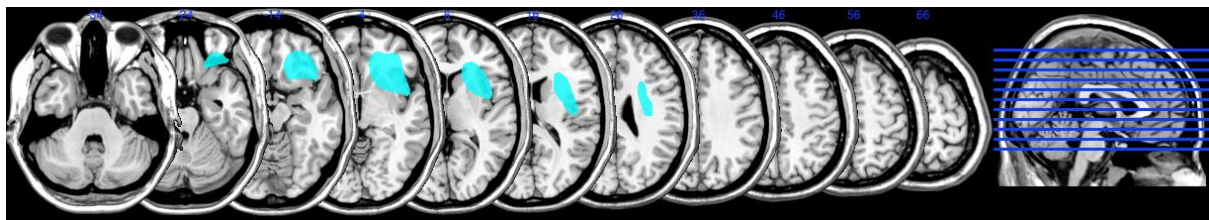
MRI scan of patient JB
